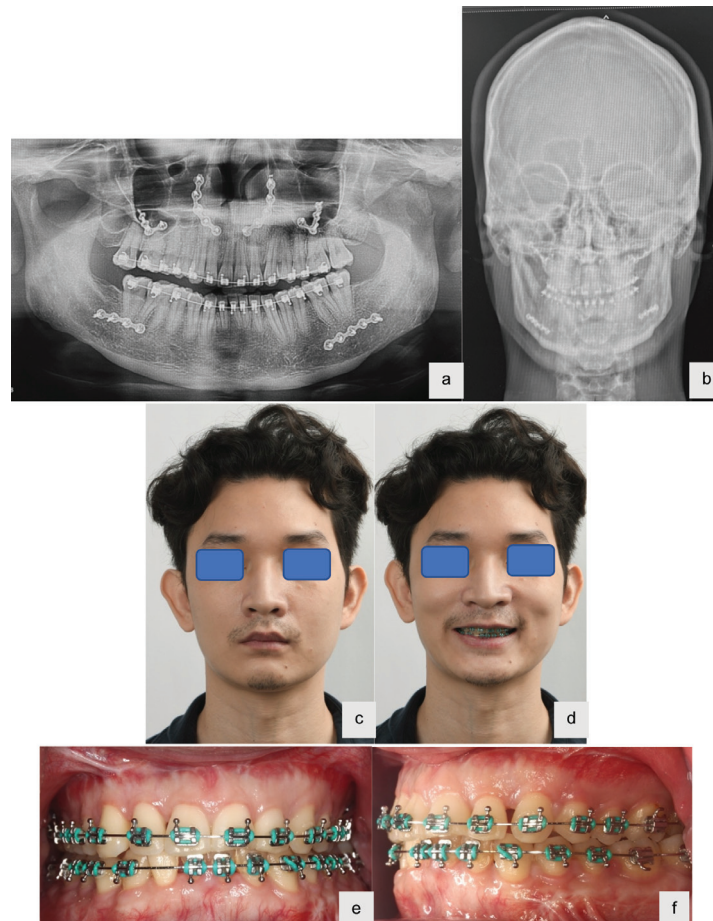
The six-month- postoperative follow-up. The panoramic and PA skull radiograph indicated that there was no recurrence of the tumor (a, b). No facial weakness was observed, and the facial asymmetry was corrected together with achieving the correct occlusion (c, d, e, f).
